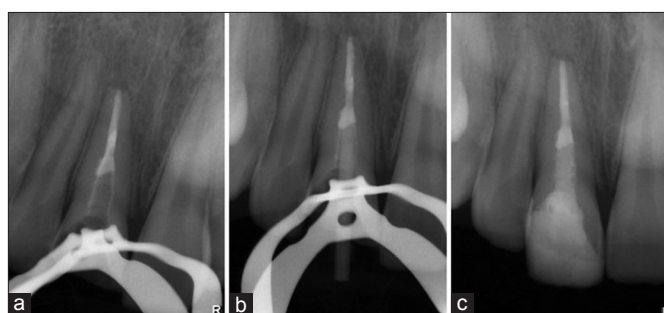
Post-endodontic radiographs, (a) apical seal with gutta-percha, (b) fiber post placement for retention (c) post endo restoration.
